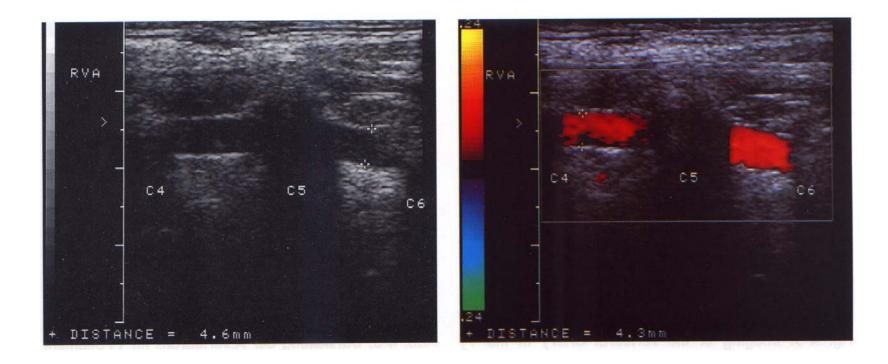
Duplex image (including B-mode and Doppler) of the vertebral artery
